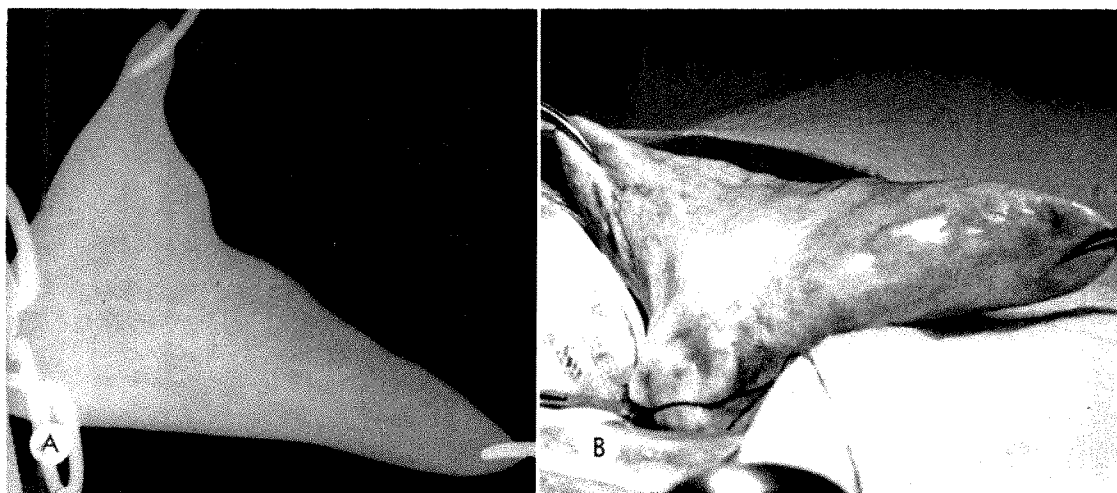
Roentgenogram (*A*) and photograph (*B*) show total collapse and lack of aeration when the bronchus of the exteriorized lobe is open to atmospheric pressure.
